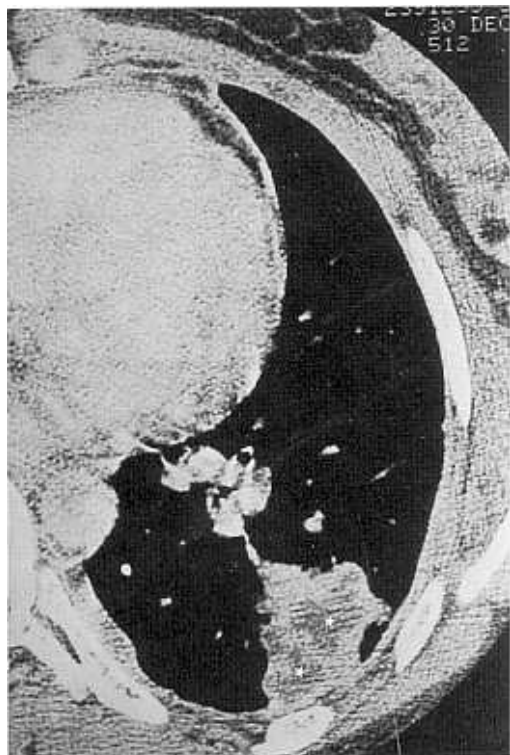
HRCT scan from a woman 28 years of age with paragonimiasis.
